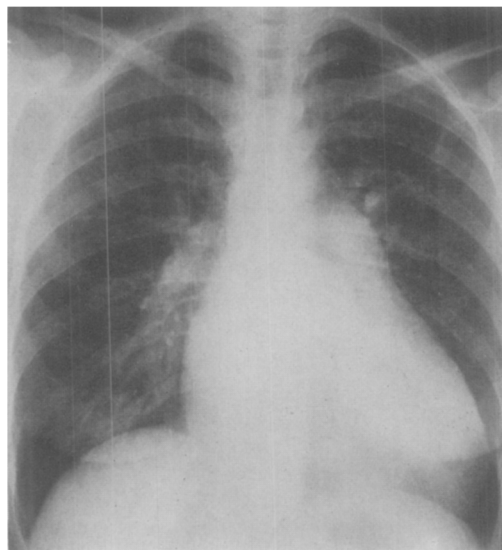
Case 4. Chest roentgenogram. No evidence of abnormal vasculature of left upper lung field.
